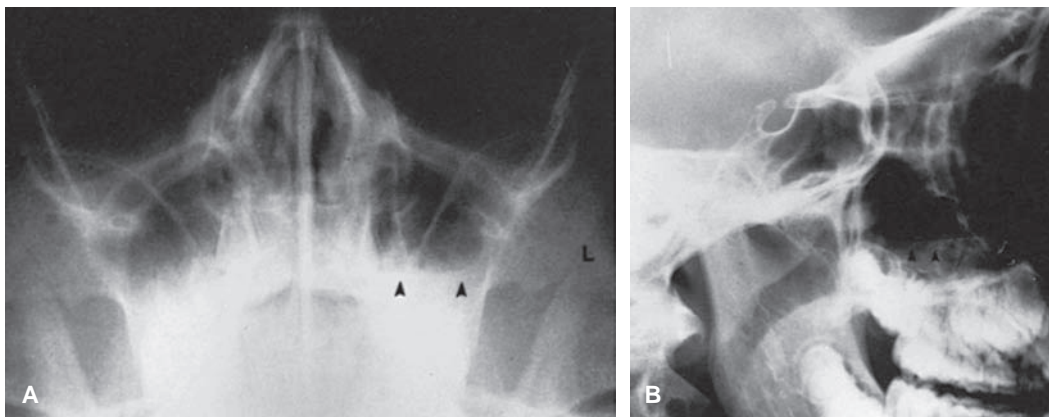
Anteroposterior (A) and lateral (B) radiographs show an air–fluid level in the left maxillary sinus (arrowheads) and mucoperiosteal thickening on the right side.
